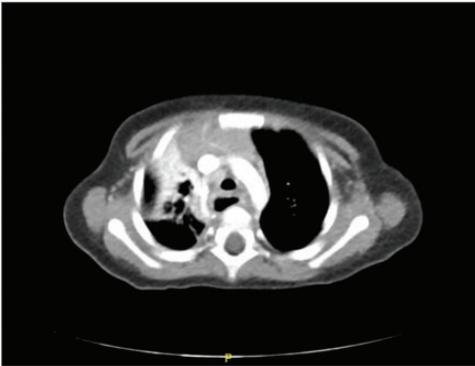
Chest computed tomography showing the upper trachea and dilated oesophagus with mediastinal collection and collapse/consolidation changes in the right lung apex.
